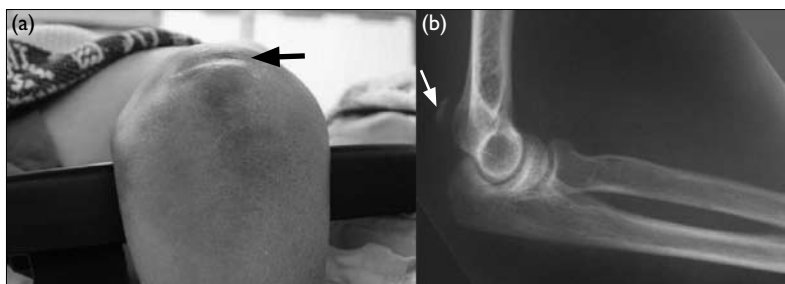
(a) Preoperative photograph shows the 'gap' sign just proximal to the olecranon at the insertion of triceps tendon (black arrow). (b) Lateral radiograph of the injured elbow showing the 'flake' fracture avulsed from the olecranon (white arrow)
